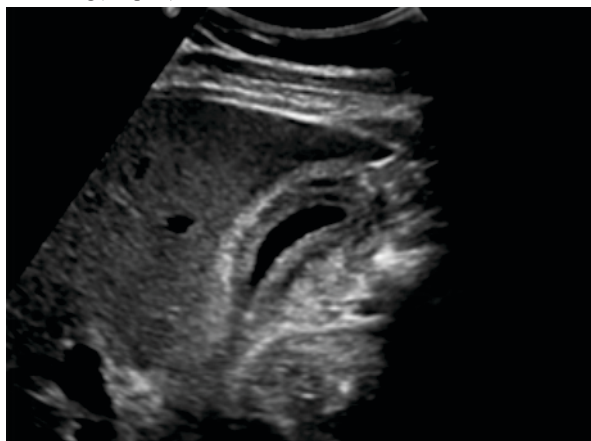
Ultrasound appearance of a striated pattern (multiple linear hypoechoic layers separated by parallel echogenic layers).
